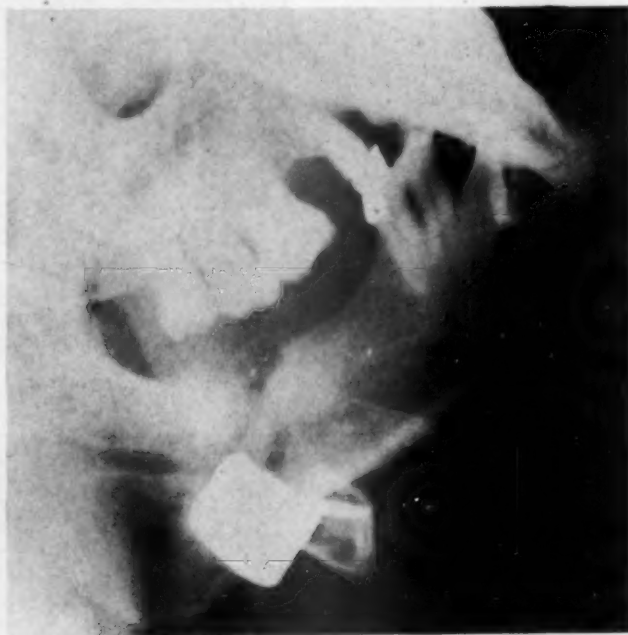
Postoperative x-ray showing the peripheral bone clamp holding the oblique fracture in position.
